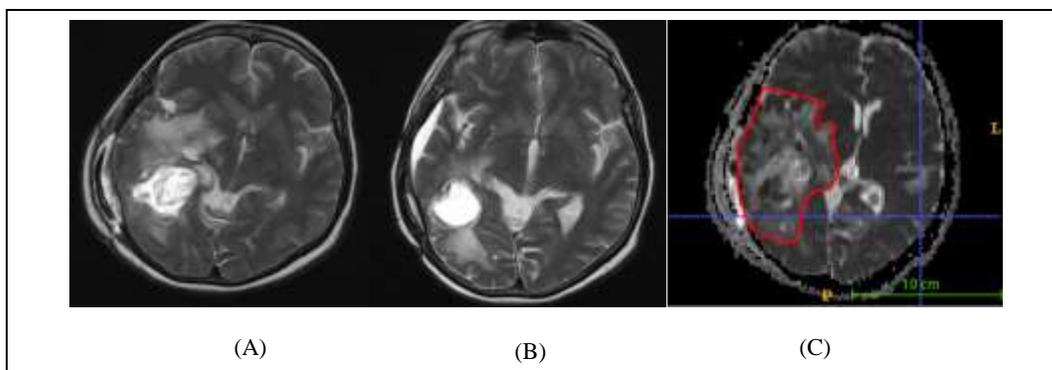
Typical changes in MRI features are demonstrated in the images
